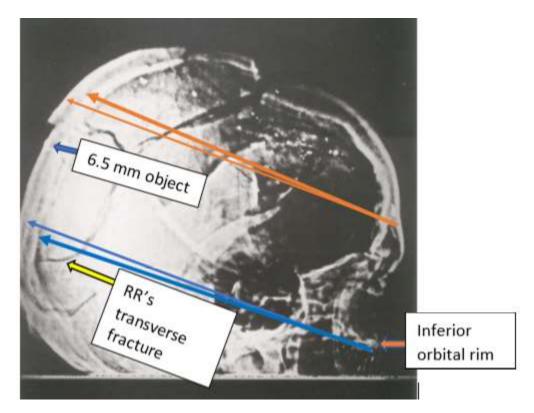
The inner orange and blue lines are parallel to one another. The outer orange and blue lines represent the directions that individual rays of the X-ray beam would have traveled while the *AP X-ray film* was being exposed. Notice that the blue lines graze the lower border of the inferior orbital rim.
